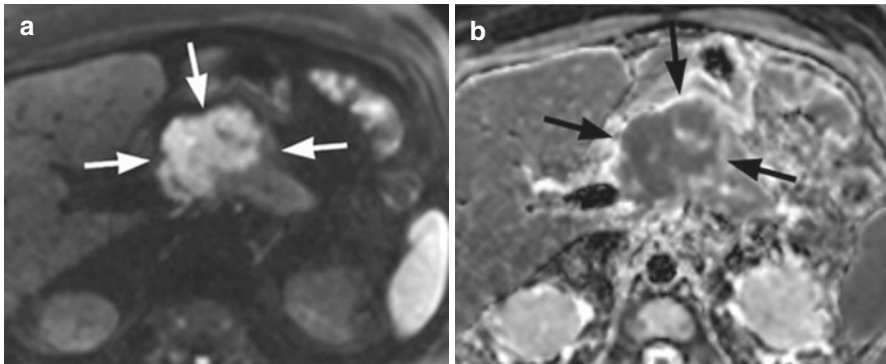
Diffusion-weighted MR imaging. (a) Diffusion weighted image (DWI) of a PDAC at a b-value of 800 s/mm² reveals high signal intensities (arrows) as marker of restricted water diffusion within the tumour. The b-value describes intensity and time profile of the gradient pulse used. (b) Corresponding ADC map with predominantly low signal intensities (low ADC values) in the tumour area (arrows). Heterogeneity can also be noted
